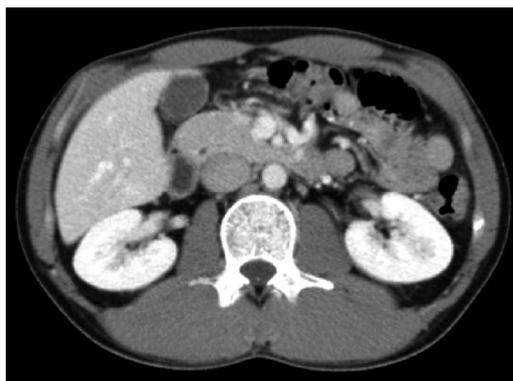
Abdominal computed tomography on hospital day 4 revealed mild pancreatic enlargement.
